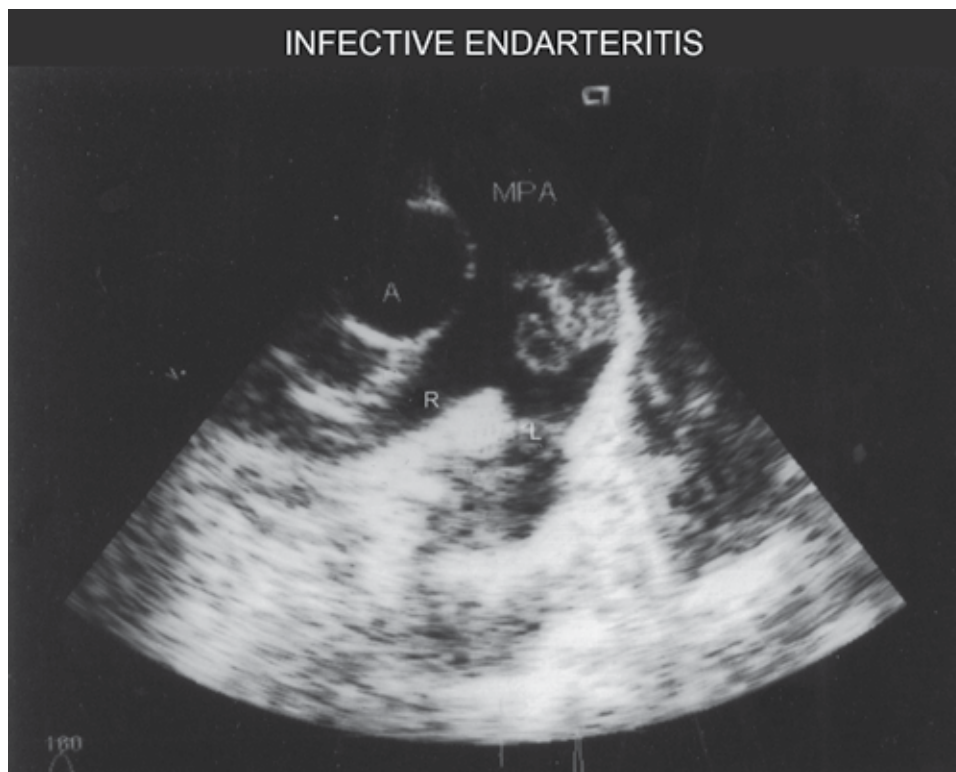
Transthoracic echocardiogram - Short axis view showing dilated main pulmonary artery with two polypoid vegetation on it's left wall.
